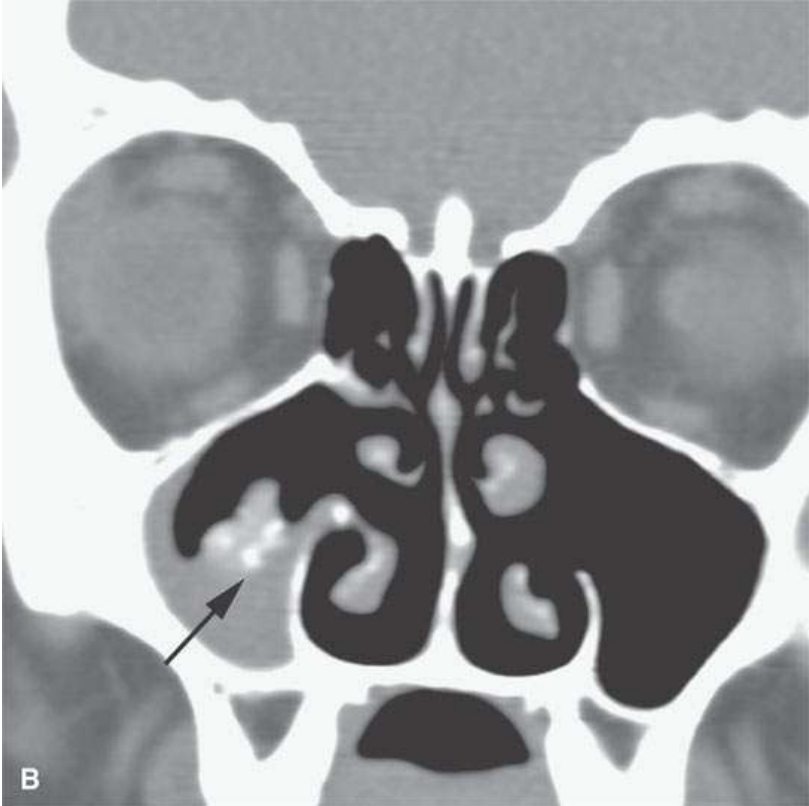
Sinus “calcifications” continued. A: Typical computed tomography (CT) pattern of dystrophic mucosal calcification. B: Relatively typical, proven CT fungal “calcification” pattern centrally within the luminal secretions (*arrow*). C, D: More ambiguous pattern with *arrows* suggesting dystrophic mucosal “calcification” and *arrowheads* suggesting fungal calcification. No fungi were found at surgery.
